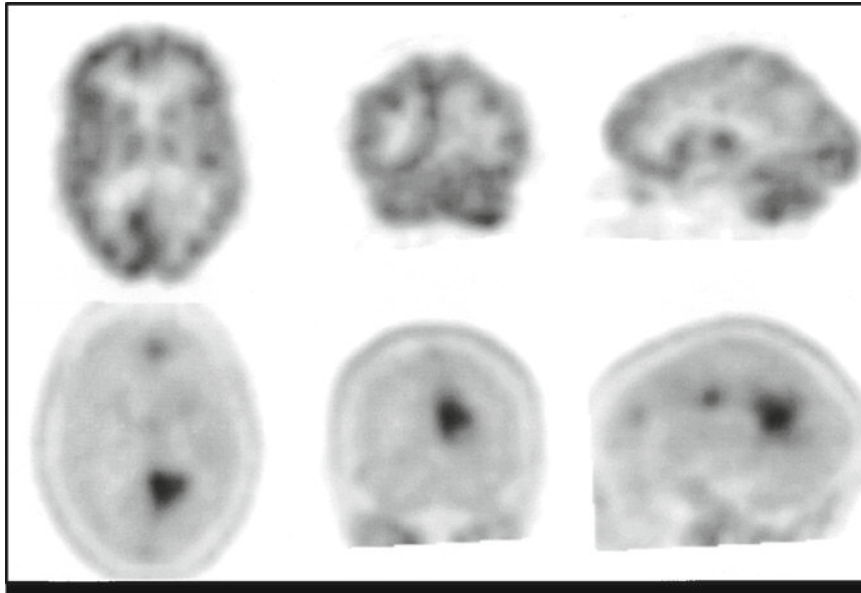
Comparison of glucose metabolism as measured by FDG-PET (*upper row*) and uptake of the amino acid FET (*lower row*) in a 72 year old female patient with glioblastoma. Apparent defect of FDG uptake e.g., in the left occipital cortex, but metabolic activity is higher than white matter activity. The distribution of FET clearly delineates the tumor and shows tumor growth along the corpus callosum, which is typical of glioblastoma (*left: axial slices, middle: coronal slices, right: sagittal slices*)
